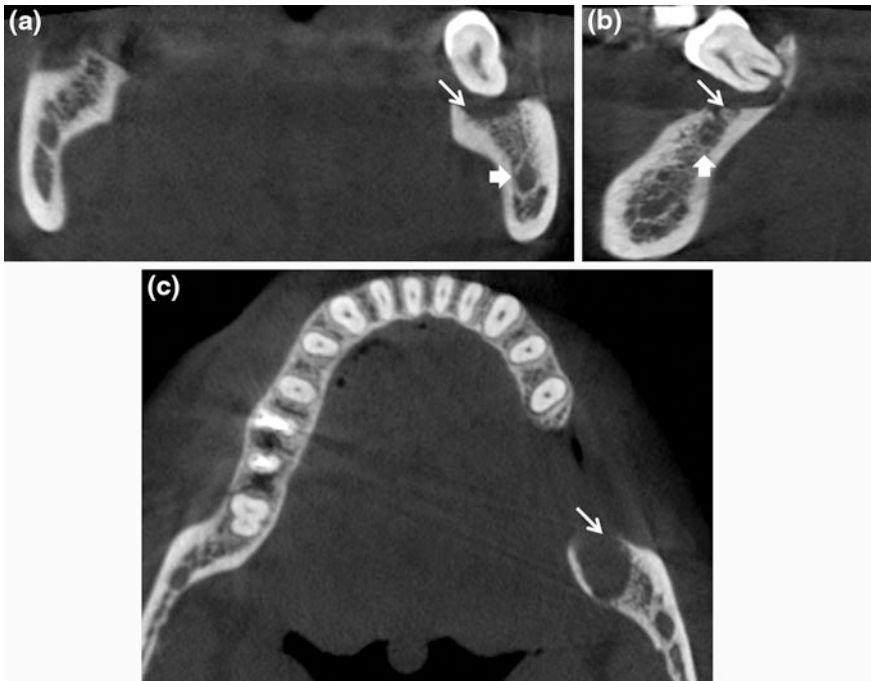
CBCT coronal (a), sagittal (b) and axial (c) sections showing a radiolucent area in close proximity to teeth 38 (*thin arrow*). The mandibular canal (*arrow*) is not involved
